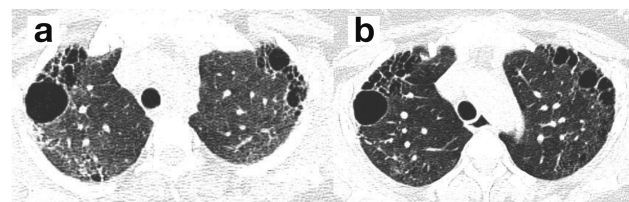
a) High-Resolution Computed Tomography (HRCT) chest done antenatal at admission showing sub pleural honeycombing and ground-glass opacity in both upper lobes. b) Repeat HRCT chest done post-natal after three weeks of systemic steroids, showing improvement in ground-glass opacity.
